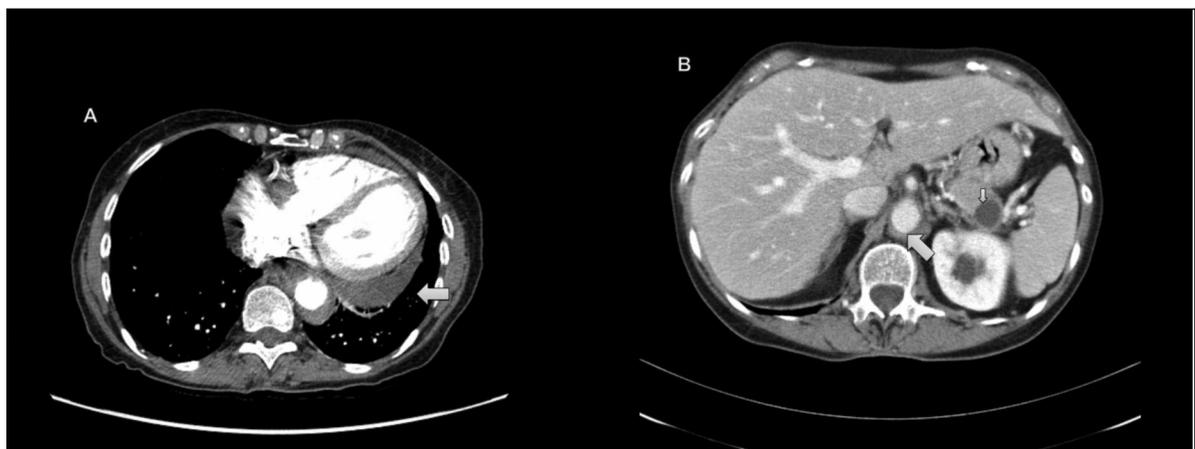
A. Three months follow-up CT scan of the chronic periaortitis. A. (Thoracic axial view) regression of the periaortic thoracic mass and of the pericardial effusion (arrow). B. (Abdominal axial view) regression of the inflammatory periaortic tissue (big arrow) and the evolution into a cyst of the initial hypodense area in the body and tail of the pancreas (pancreatitis)(small arrow).
